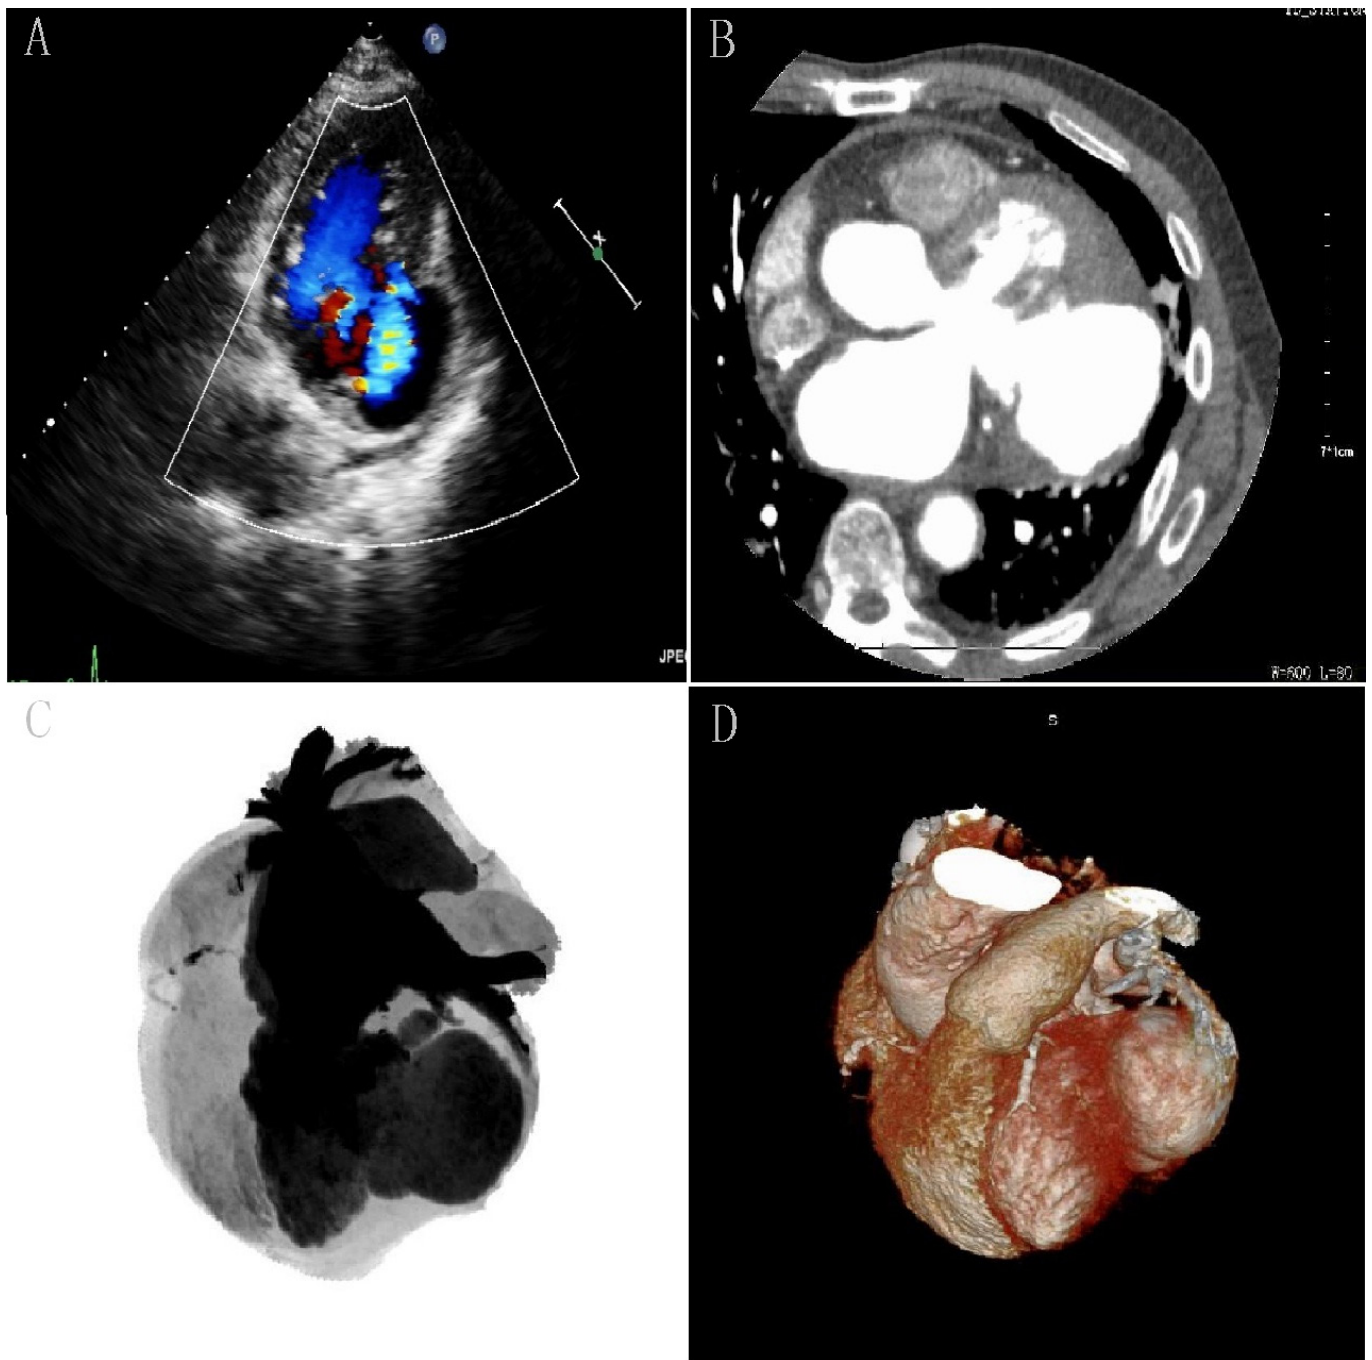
A) Doppler showing flow passage from the left ventricular into the pseudoaneurysm. B, C, D) Multislice computed tomography revealing a progressive pseudoaneurysm measuring  $67 \times 46 \times 60$  mm originating from the LV posterolateral wall.
